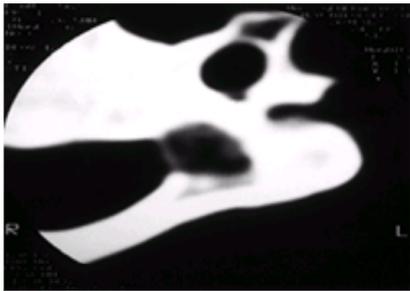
This is a computed tomography scan cut through a lesion in the pedicle of a teenager with neck pain. The lesion has all of the characteristics of osteoid osteoma. It could not be seen clearly on the plain radiograph, but there was a discrete focus of increased uptake on a technetium 99 bone scan.
